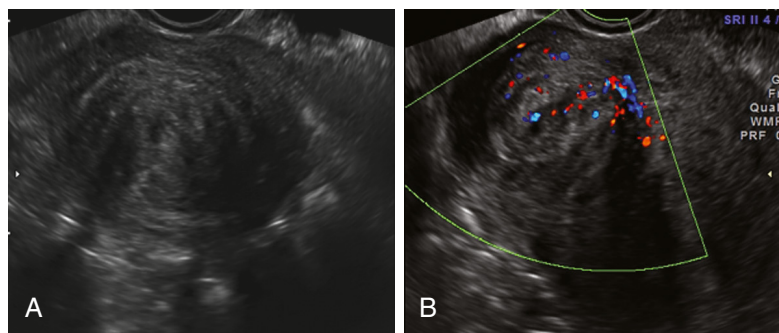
Myomas typically demonstrate mostly peripheral flow on color or power Doppler. (A) Transverse view of a uterus with a fundal myoma demonstrating a rounded, well-defined lesion with acoustic shadowing; (B) on color Doppler a myoma has diffuse, but mostly peripheral flow.
